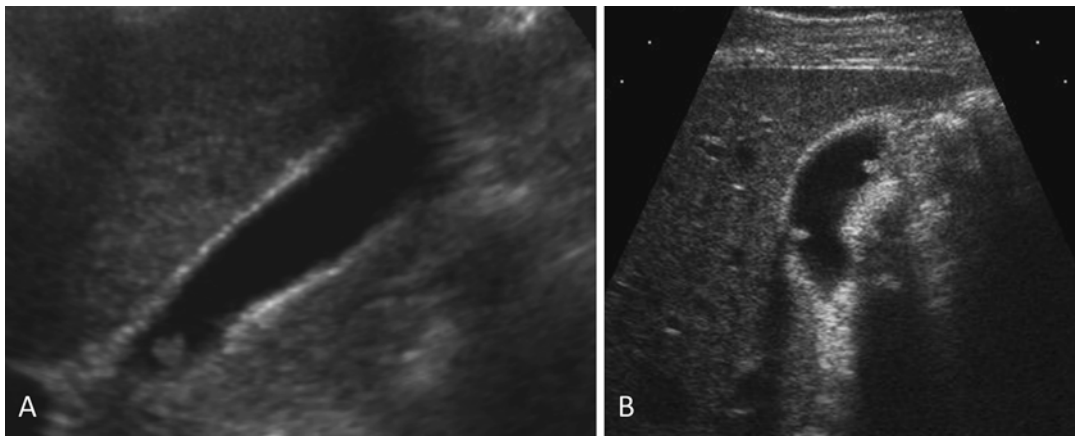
Gray-scale ultrasound of the gallbladder demonstrating polyps. (a) Single polyp in the gallbladder neck. (b) Multiple polyps located throughout the gallbladder
